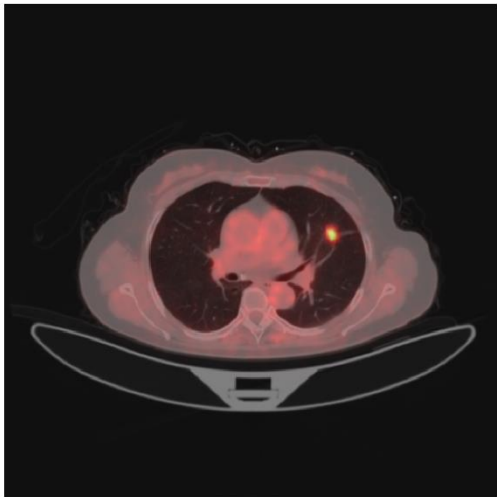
A sample of merged PET/CT image showing a cancerous tumor in the left lung
